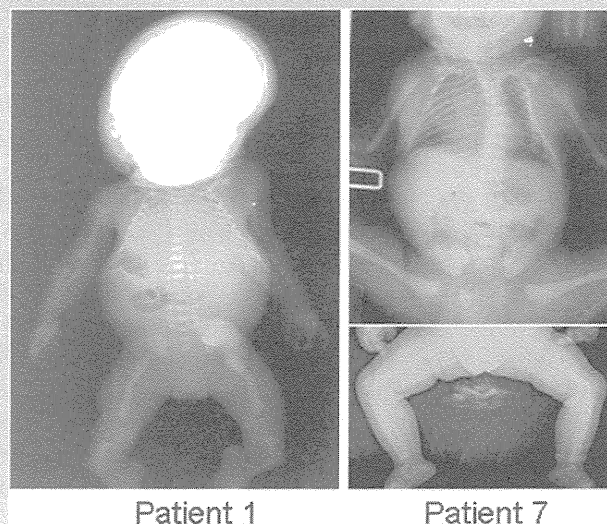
Representative roentgenograms indicating CD in patient 1 at birth and ACD in patient 7 at 3 months of age.
